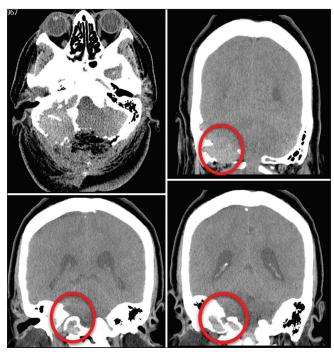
Six-month postoperative CT scan of Case 2 in axial and coronal views. Bilateral progressive widening of the cancellous bone of the squamous portion of the occipital bone and of the left condyle can be observed. There is also invasion to the adjacent petrous bone. It has been referred to as an osteolytic lesion without a sclerotic border. There is residual unresectable tumor due to blood loss during surgery.
